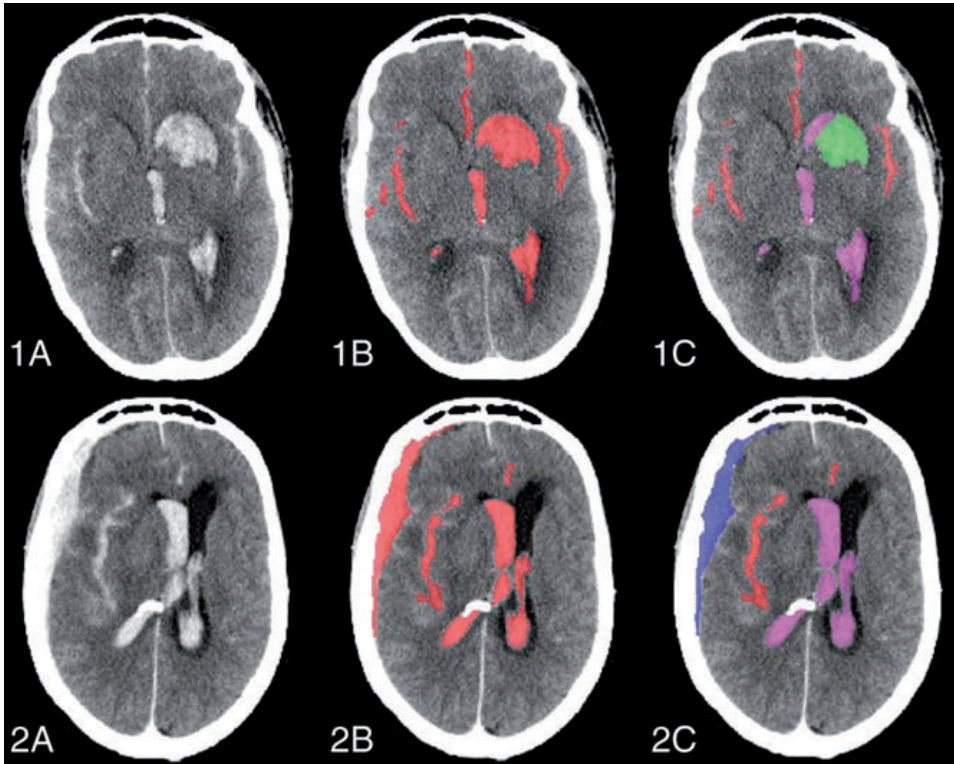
Classification of the total blood volume as cisternal, intraventricular, intraparenchymal, and subdural. 1A, Axial slice of a noncontrast CT of a patient with aSAH with concomitant IVH and IPH. 1B, Quantified total blood volume. 1C, Classified cisternal (red), intraventricular (magenta), and intraparenchymal (green) blood. 2A, Axial slice of a noncontrast CT scan of a patient with aSAH with concomitant IVH and SDH. 2B, Quantified total blood volume. 2C, Classified cisternal (red), intraventricular (magenta), and subdural (blue) blood.
